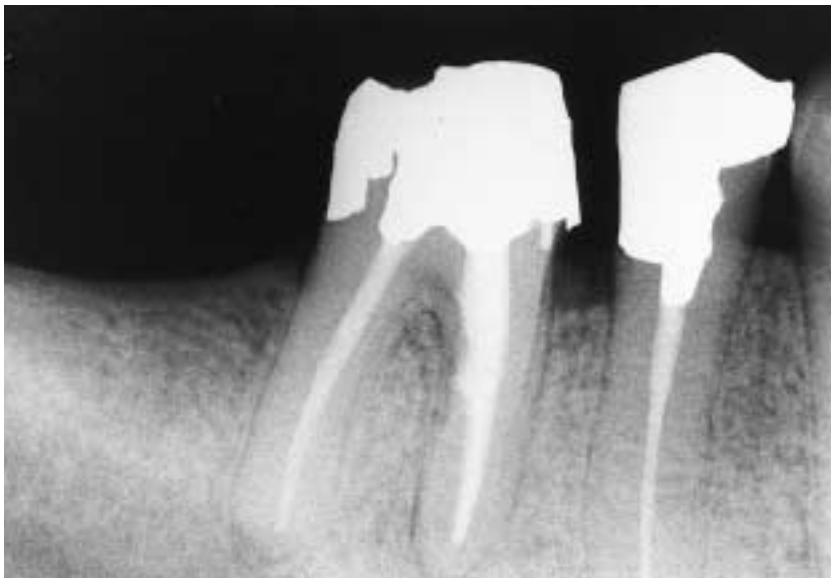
At a six-month recall visit, there was radiographic evidence of bone fill in the furcation and probing depths were back to 4 millimeters. The patient was asymptomatic.
